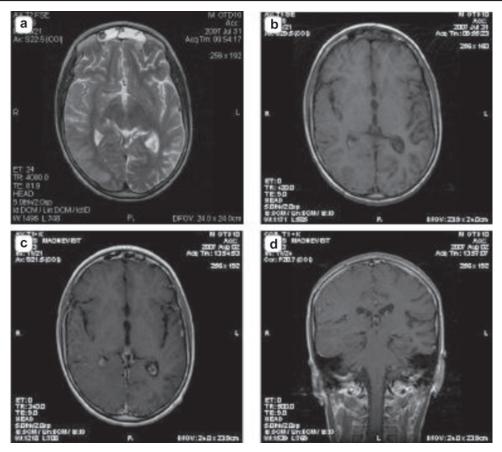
Patient T., 14 years old. Acute viral encephalitis. 0,5 T MRI:
